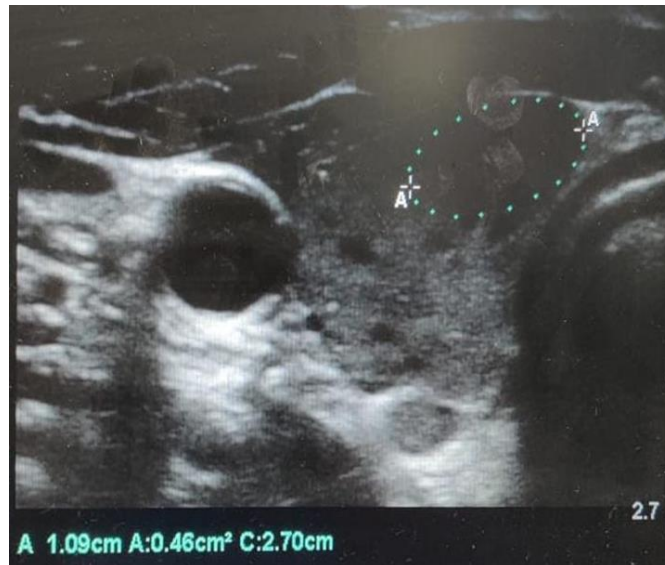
Ultrasound of neck of right thyroid lobe showing 2.7x 1.09 cm hypoechoic lesion
